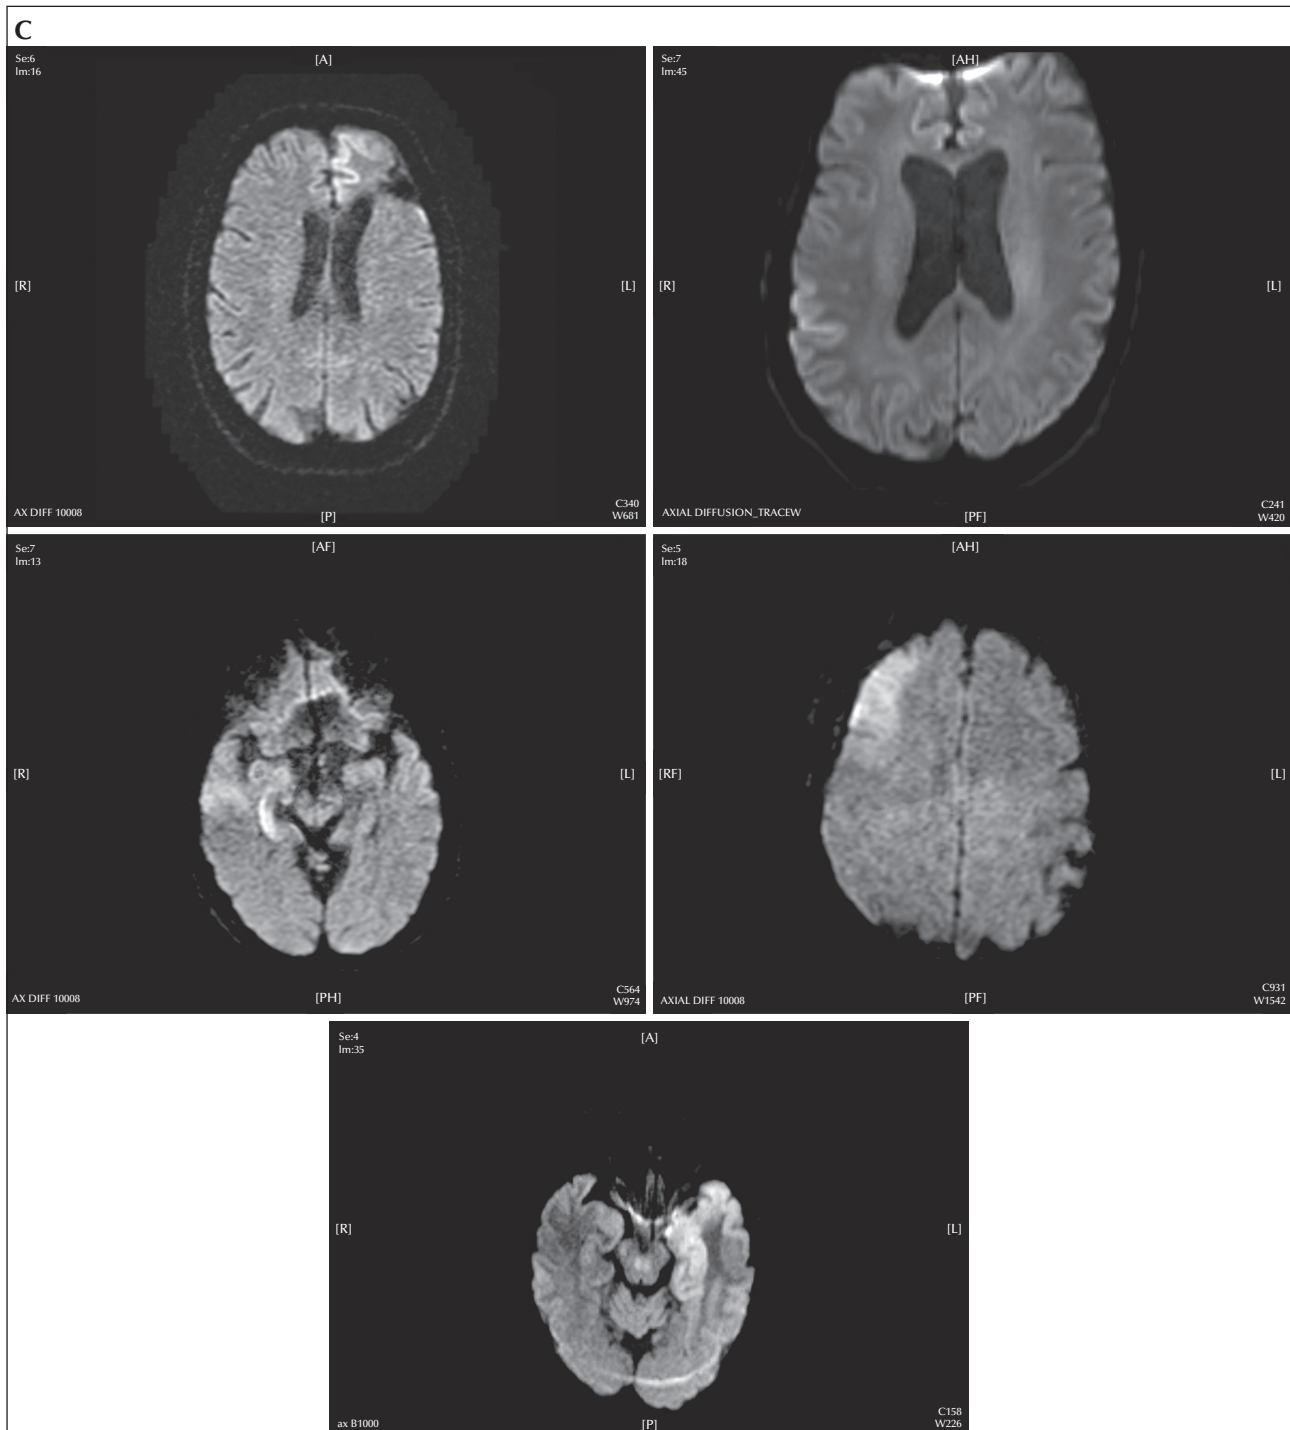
Brain MRI images showing restricted diffusion pattern in the region of the PLEDs in the five patients who had PLEDs and electrographic seizure patterns on their EEGs (Patients 6-10).
